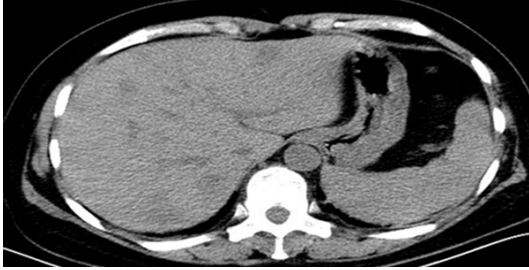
Presentation of Case 3. CT scan showed multiple hypodense nodular lesions in the liver and spleen.
